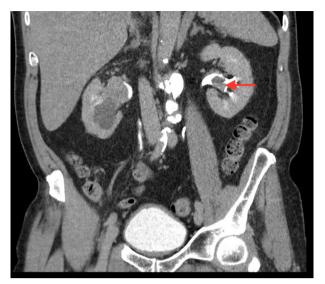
CT urogram of urothelial cancer.
